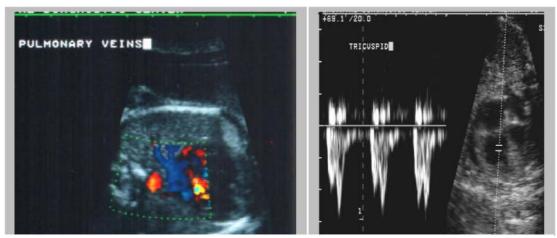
Color and PW Doppler echocardiography allows us to assess the overall cardiovascular condition of the fetus and thus provide sophisticated management.
